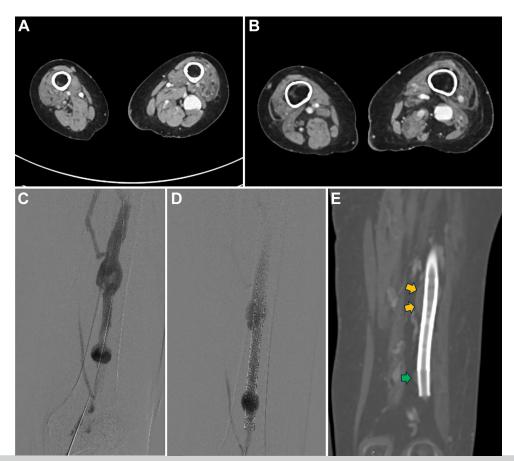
Axial computed tomography venography (CTV) images depicting left profunda femoris vein aneurysms in patient 3: superior aneurysm (A) and inferior aneurysm (B). CTV demonstrating left profunda femoris vein aneurysms in patient 3: before stent exclusion (C) and after stent exclusion (D). Note the continued filling of the aneurysm sacs after exclusion. This is expected, with thrombosis occurring subsequently, given the venous flow properties. D, Coronal CTV image 8 months after intervention depicting left profunda femoris vein aneurysms in patient 3 that have since undergone successful stent exclusion. *Arrows* depict thrombosed sac: *orange arrows*, superior aneurysm; and *green arrow*, inferior aneurysm.
